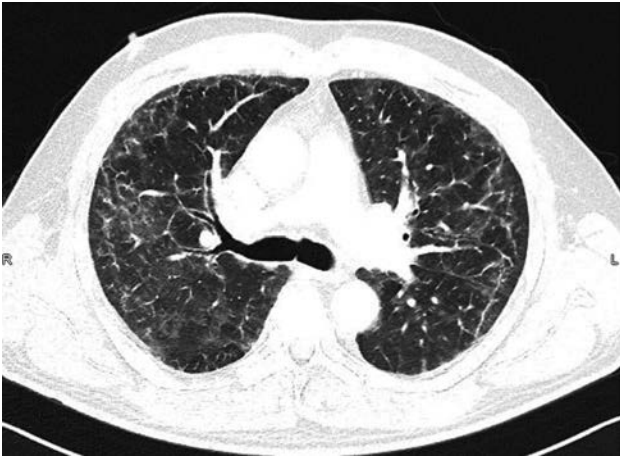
Chest computed tomography of a melanoma patient receiving precision immunotherapy with ipilimumab and nivolumab. Pneumonitis with diffuse alveolar damage is observed including reticular markings, traction bronchiectasis and ground-glass opacities.
